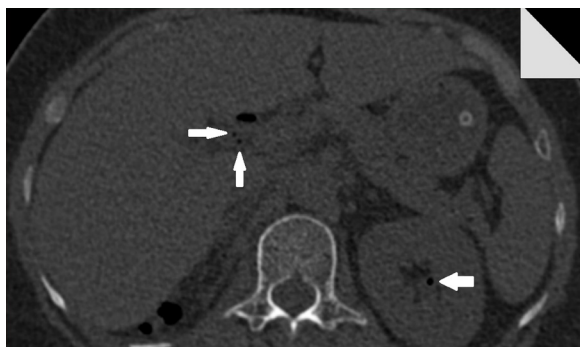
A non-contrast CT scan of the abdomen revealed gas collection in the right kidney.
